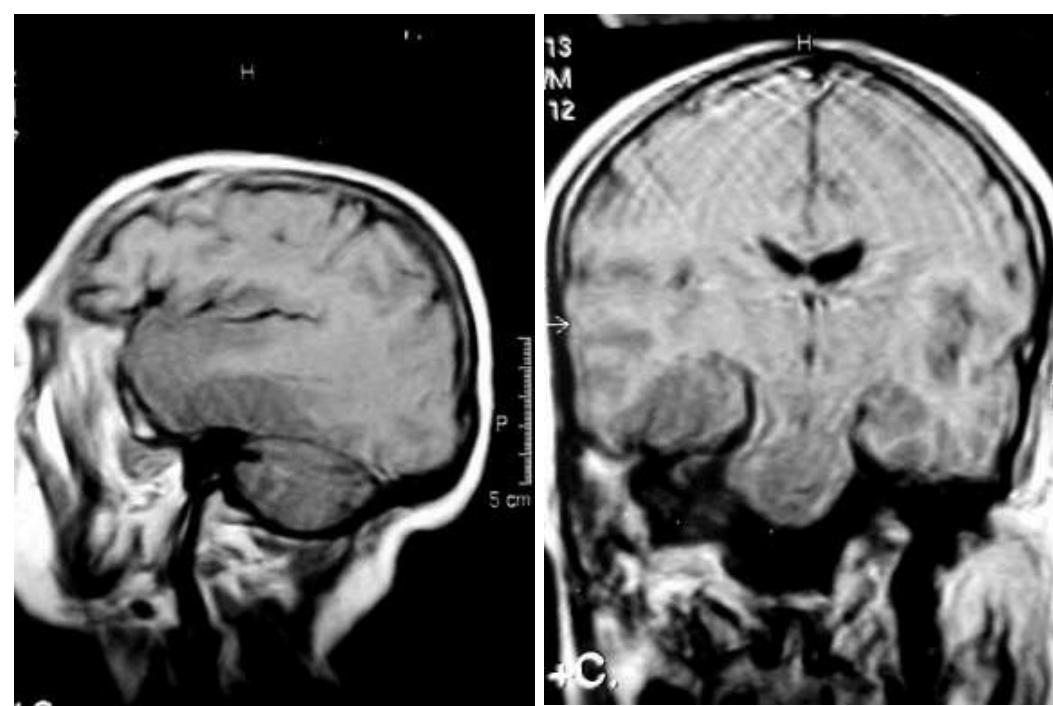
Herpes simplex encephalitis. Postcontrast MRI T1 images. Notice the cortical (gray matter) hypointensity involving the temporal lobes bilaterally, more on the right side (A,B). The signal changes are almost exclusively cortical involving the medial (amygdala, hippocampus) and the lateral temporal cortical area, bilaterally more on the right side. Notice the insular hypointensity on the left side (A).
